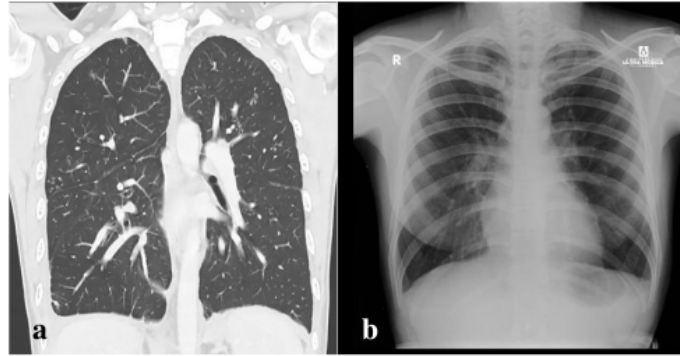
(a) Initial Thorax CT scan showing Tb process, (b) Normal chest x-ray evaluation
